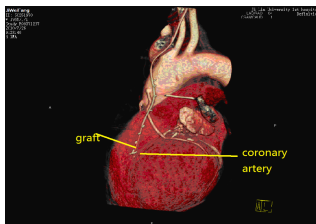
CT angiography of CABG
